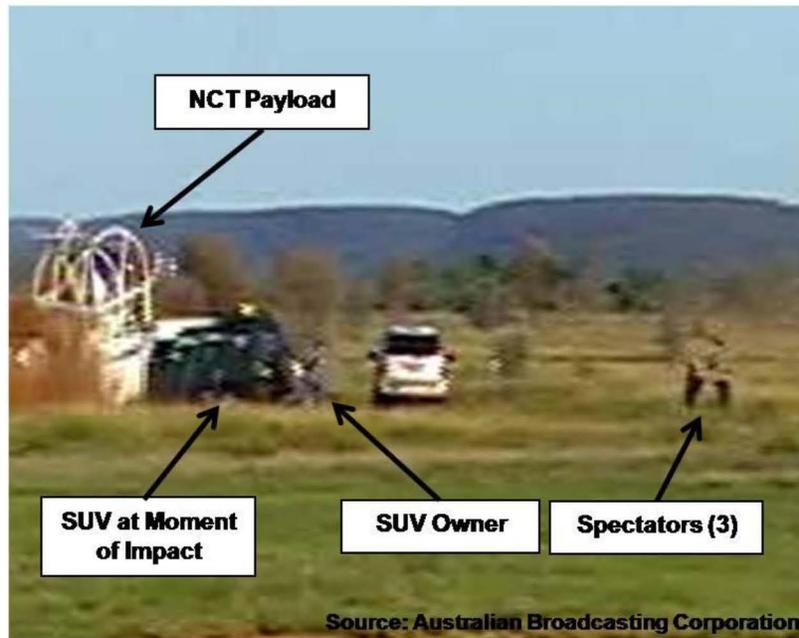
SUV Owner Running Just Before the SUV Was Impacted
